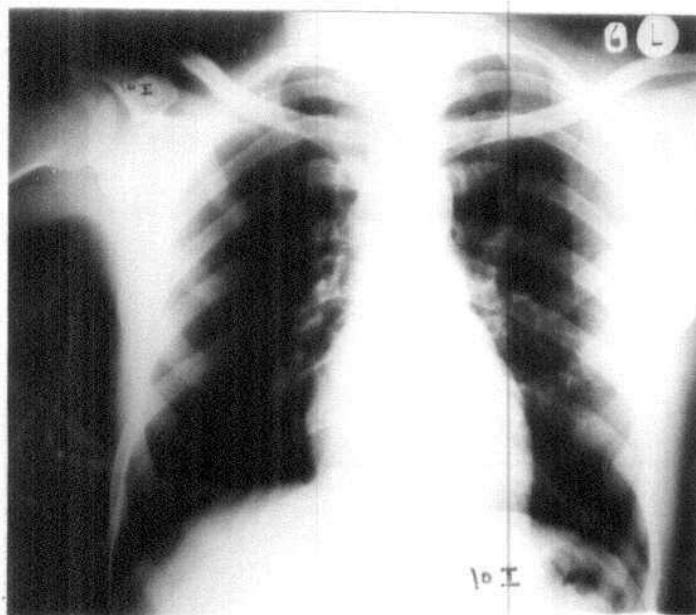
Preoperative chest radiograph for patient No. (10 I): No active lung lesion.
